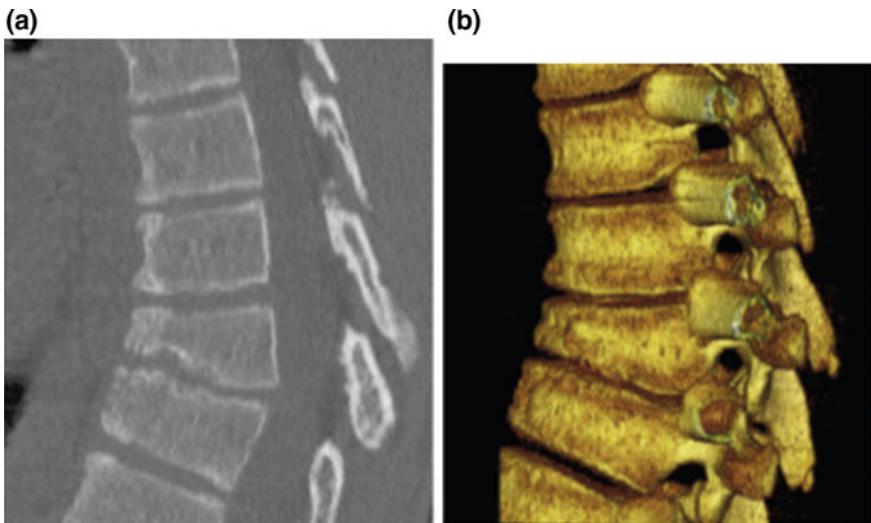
Scheuermann's kyphosis in a 15-year-old boy. a Sagittal 2D CT reconstruction image demonstrates midthoracic kyphosis with anterior wedging of at least three consecutive vertebrae with presence of Schmorl nodes. b Sagittal 3D CT reconstruction image demonstrates midthoracic kyphosis with anterior wedging of at least 3 consecutive vertebrae and the presence of Schmorl nodes. Republished with permission of Rodriguez and Poussaint [1]
